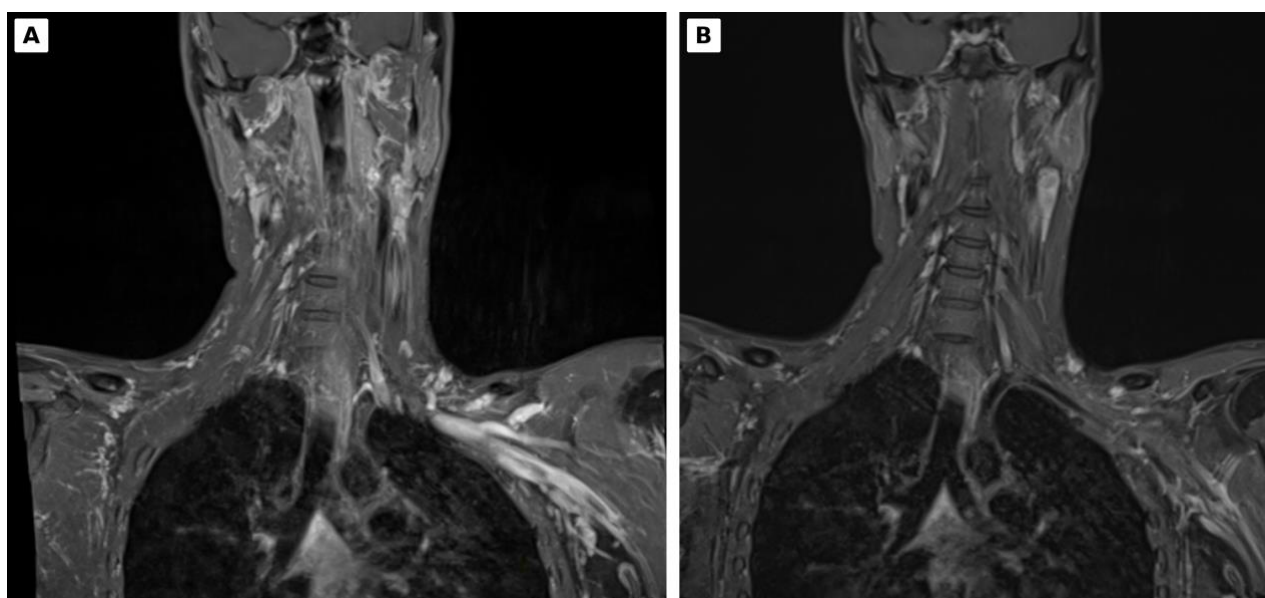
Coronal post-gadolinium T1-weighted fat-suppressed images demonstrate enhancement of the bilateral cervical nerve roots and brachial plexus components, with asymmetric severity.
